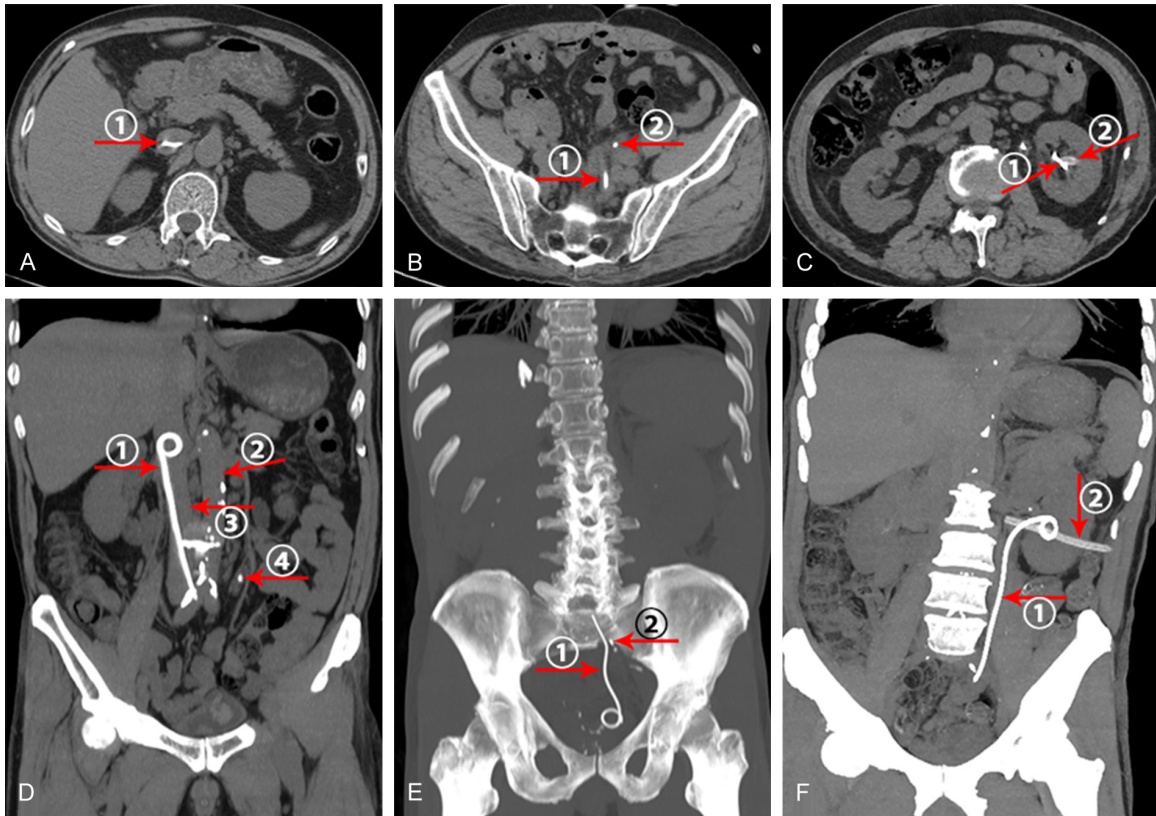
(A, B, D and E) show the first postoperative plain CT scans of the patient. (C and F) show the second postoperative CT scans of the patient. (A. ①, B. ①, C. ①, D. ①, E. ①, F. ①) are double J tubes; (B. ②, D. ④, E. ②) are ureteral calculi; (C. ② and F. ②) are nephrostomy tubes; (D. ②) Abdominal aorta; (D. ③) is the inferior vena cava.
